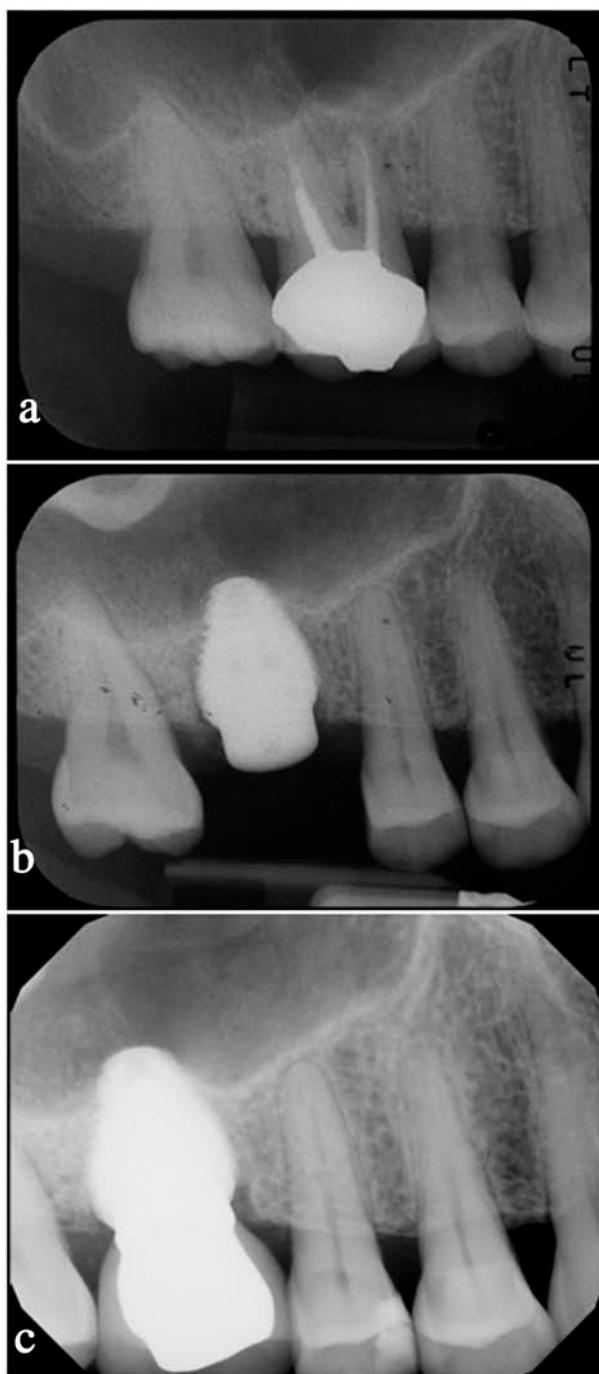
(a) Failed endodontic treatment necessitated the removal of the maxillary right first molar which was de-coronated and sectioned to allow the roots to be removed individually. There was extensive periapical granulation tissue around the mesiobuccal root, and this was removed using curettes. An 8-mm diameter (ultra-wide) by 8-mm long moderately rough implant was inserted at the time. (b) The immediate postoperative radiograph taken at placement of the IMI. The site was developed using hand profilers which allowed localized sinus floor elevation without adding graft material. (c) The 6-year follow-up radiograph of the restored implant.
